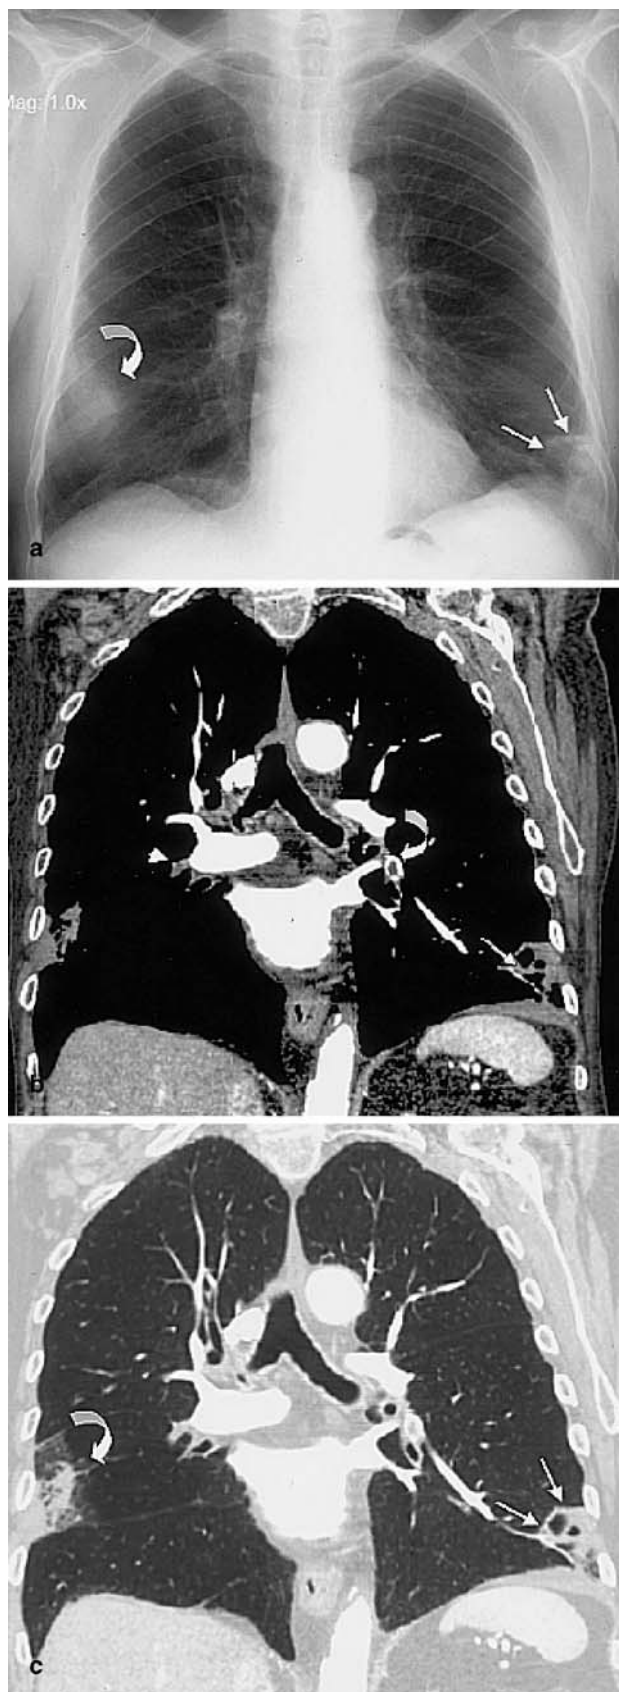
A 72-year-old man with recurrent chest pain and dyspnea. This patient had previous thromboembolic disease treated with anticoagulation and inferior vena filter placement. a Frontal chest X-ray reveals cardiac enlargement with pacemaker. Well-defined densities are present in the axillary portion of the right lung (*curved arrows*) in a configuration compatible with pulmonary infarcts. b Axial view of thin-section multislice CT (soft-tissue window settings, 1.3 mm collimation, 0.6 mm interval reconstruction) revealed the inferior pleural-based (minor fissure) wedge-shaped opacity partially aerated in the right middle lobe (*curved arrow*). The peripheral artery leading to it was thrombosed (*straight arrow*). The diagnosis of recurrent PE with pulmonary infarct was established
